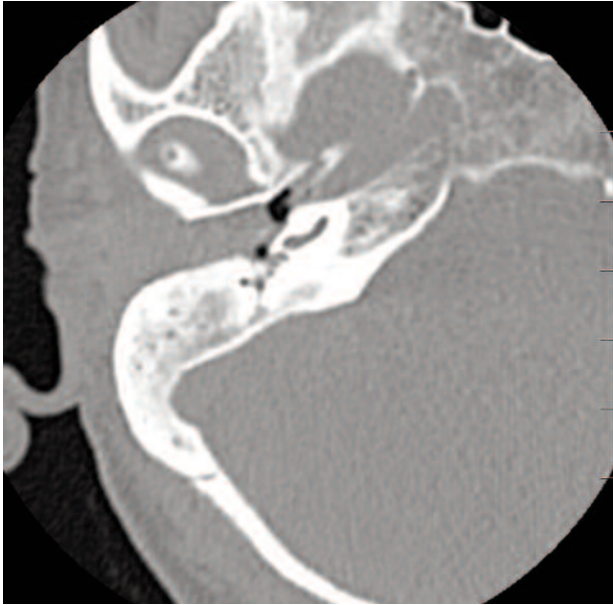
Initial CT scan (June 2006), axial plane, where soft tissue mass completely fills the right-sided external auditory canal and extends also into the middle ear.
